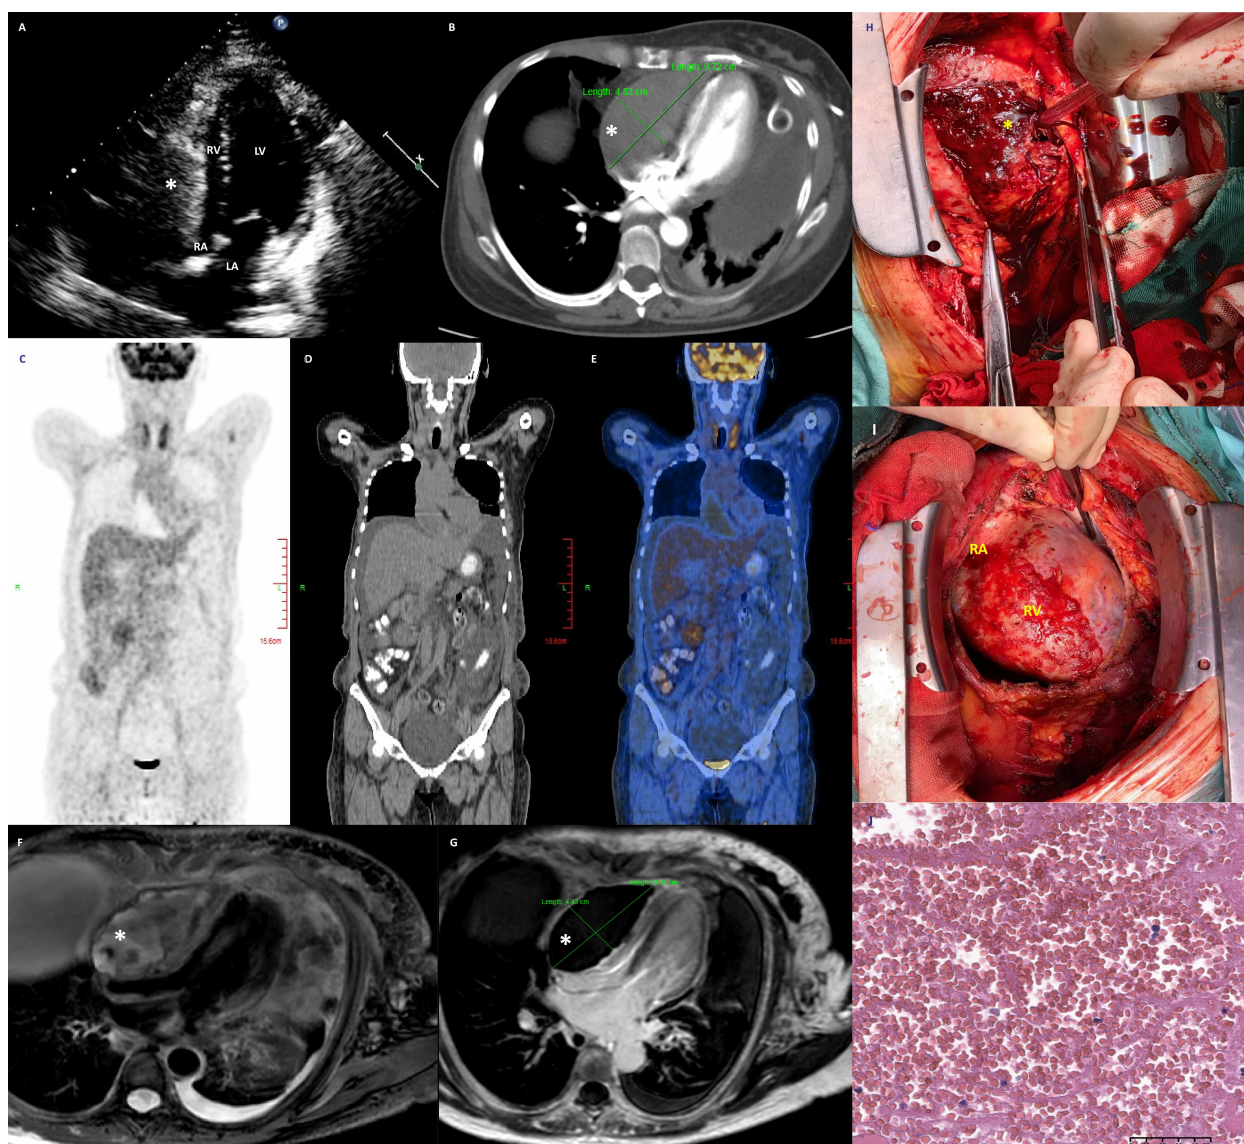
Comprehensive diagnostic and intraoperative findings of pericardial mass using multimodal imaging techniques. (A) Transthoracic echocardiogram was utilized to visualize the initial presence and position of the pericardial mass affecting cardiac function. (B) Chest enhanced computed tomography (CT) provided detailed imaging that confirmed the extent and effects of the mass on the right heart structures. (C–E) positron emission tomography-computed tomography (PET-CT) scan revealed an irregular mass shadow in the right ventricle characterized by uneven density and no evident contrast distribution, suggesting the absence of typical tumor characteristics. (F) Cardiac magnetic resonance imaging (MRI) T2WI imaging showed mixed signal intensities indicating the heterogeneous nature of the mass. (G) Cardiac MRI late gadolinium enhancement highlighted the mass's borders and lack of enhancement, further suggesting non-malignant pathology. (H) Upon surgical exploration of the pericardium, a dark red gel-like substance was observed. (I) Confirmation of the heart's intact structural integrity, with no significant breaches or hemorrhages. (J) The pathological analysis indicates the presence of bleeding, fibrin leakage, and infiltration by inflammatory cells, with no tumor cells detected, supporting a diagnosis of an inflammatory or benign etiology rather than malignancy. * Indicates the presence of a pericardial mass. RV, right ventricle; RA, right atrial; LV, left ventricle; LA, left atrial. 50 μ m, divided into 5 sections of 10 μ m each.
